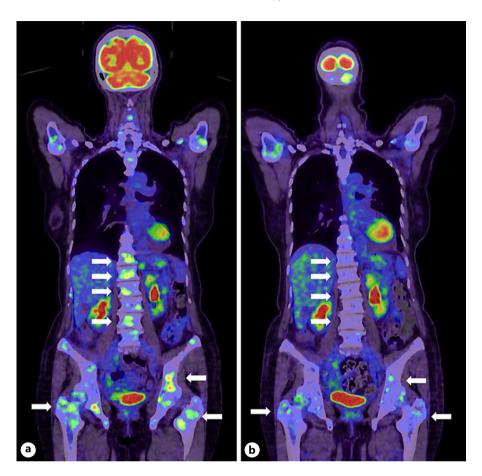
PET-CT image. a PET-CT before the start of treatment. b PET-CT image 6 months after the treatment started, showing improvement in bone metastasis.
